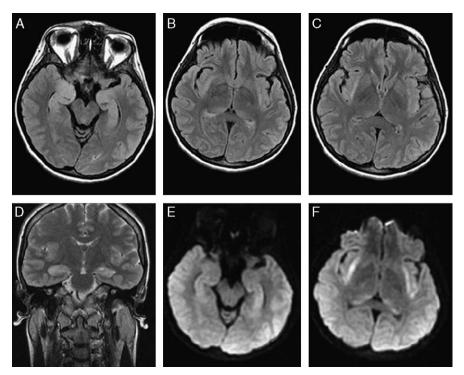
A to C, Axial T2 images; D, coronal T2w turbo spin-echo image; E and F, axial diffusion weighted images (DWI). Fluid attenuated inversion recovery and T2w images show diffuse and bilateral swelling of temporal uncus, hippocampal formation, subcortical insular white matter, and pulvinar, characterized by hyperintensity on T2wi. The highly hyperintense signal observed on DWI is related to hyperacute cellular swelling.
